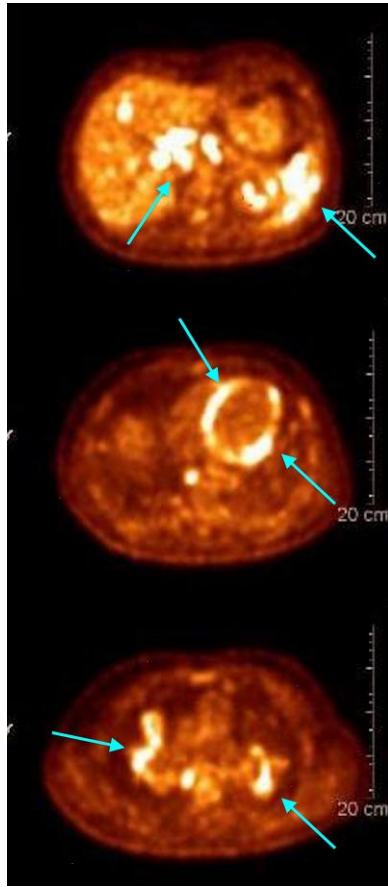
Coronal plane 18-FDG-PET images showing heart, lymph nodes, and spleen uptake of 18-fluorodeoxyglucose.
